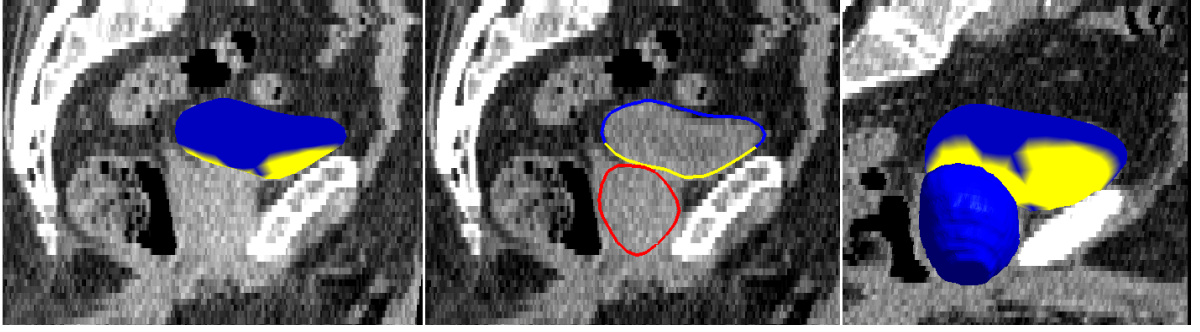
Sagittal views of a male pelvis in CT, with bladder boundary colored by region type. Left: a 3D view. Middle: the in-plane contour also colored by region type, with the prostate shown for reference. Right: an off-sagittal 3D view of the same bladder, now with the prostate also in 3D and in the foreground.
